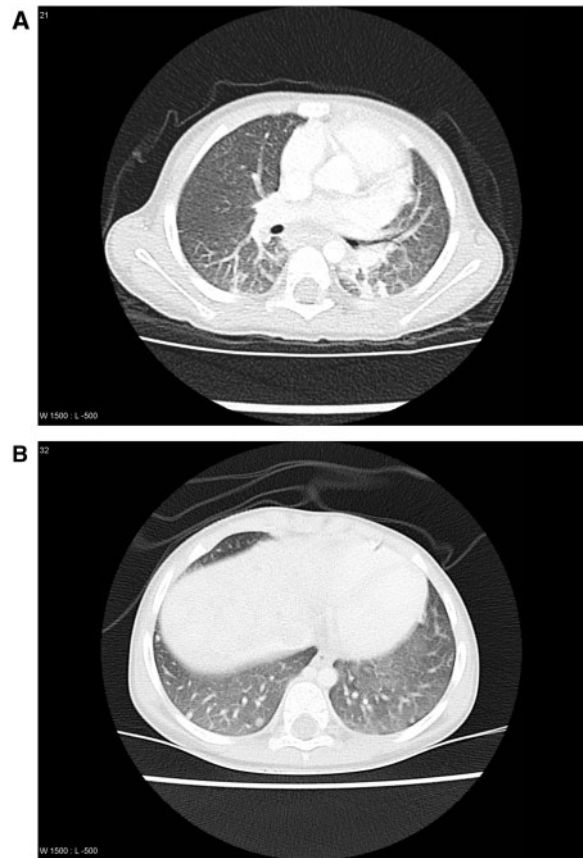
CT scan of the chest in a 2-year-old girl under general anaesthesia (a), repeated 2 weeks later under sedation (b).
